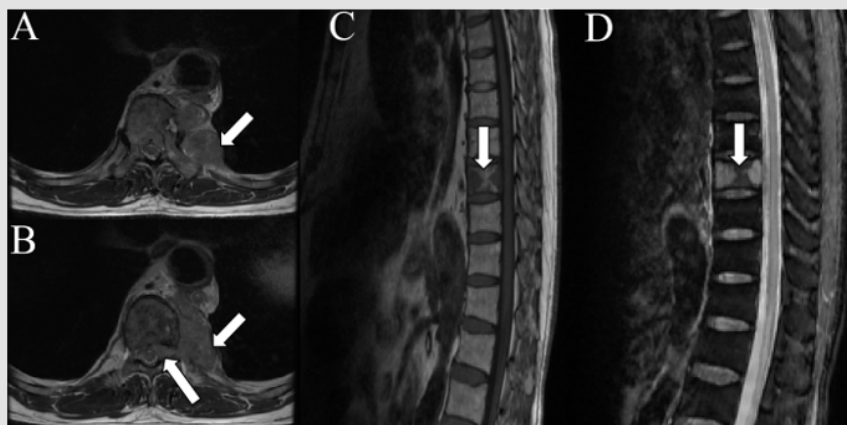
A 63-year-old man complained of the central back pain 2 years. MRI of the throactic vertebre showed the there was a mass located in the left posterior mediastinum with slightly hypointense in T1 weighted image (T1WI) (short arrow in A and B) and invaded the spinal canal through the intervertebral foramen caused the dumbbell shape (long arrow in B: T1WI). The adjacent T10 vertebral body has bone destruction (arrow, C: T1WI, D: T2WI). A malignant tumor was suspected.
